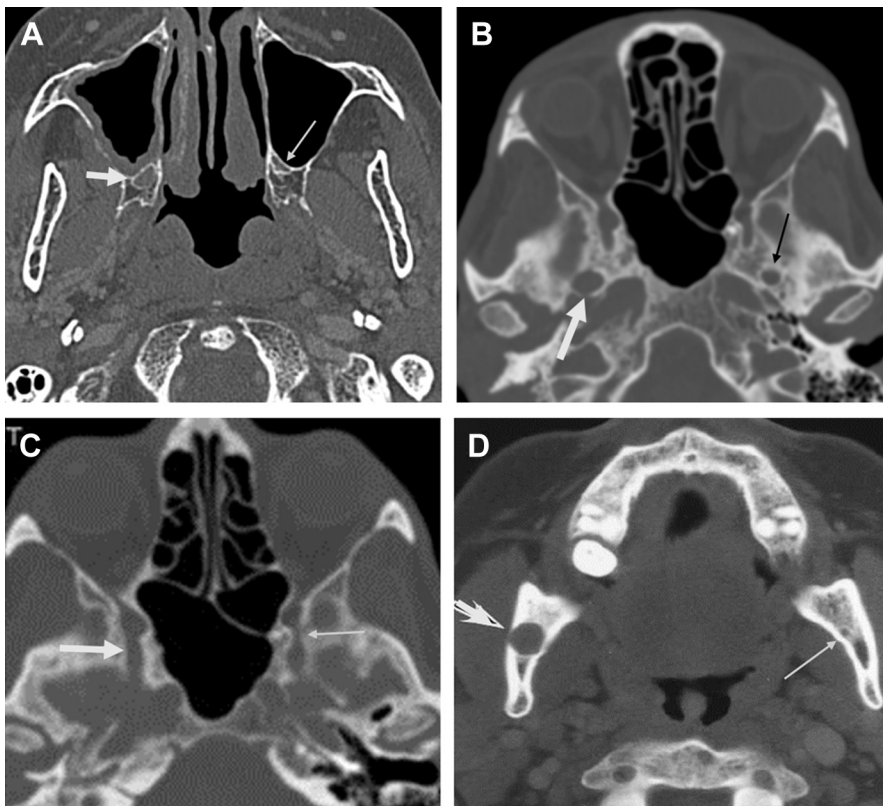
Asymmetric enlargement of a nerve canal is a reliable CT finding of PNS in the proper clinical setting, although this is usually seen in advanced stages of disease. Axial CT images demonstrate enlargement of the right palatine nerve foramen (A), the right foramen ovale (B), the right foramen rotundum (C), and the right mandibular canal (D) (*thick arrows*) in separate patients with palatine nerve, mandibular nerve, maxillary nerve, inferior alveolar nerve PNS, respectively. Thin arrows point to the corresponding normal left sided nerves.
